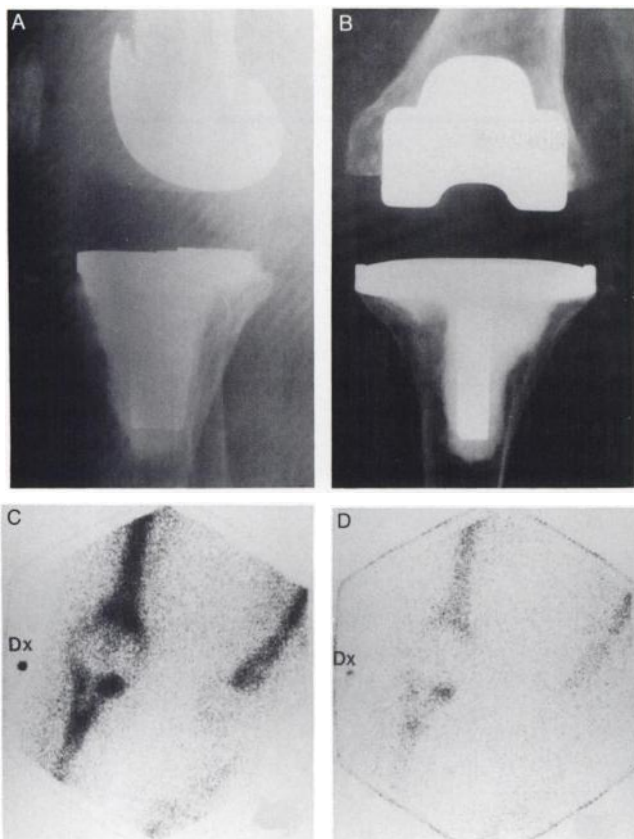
Case 16. Sixty-eight-year-old female with history of rheumatoid arthritis and a knee prosthesis for 1 yr. The patient experienced pain on weightbearing and at rest. (A) Radiographs show no signs of loosening. (B) Technetium-99-NCS shows increased uptake (++) corresponding to the distal femur and proximal medial tibia. (C) The uptake with ^{111}In -LS was classified as slightly increased (+). Bacterial cultures at operation were positive for *staphylococcus epidermidis*.
